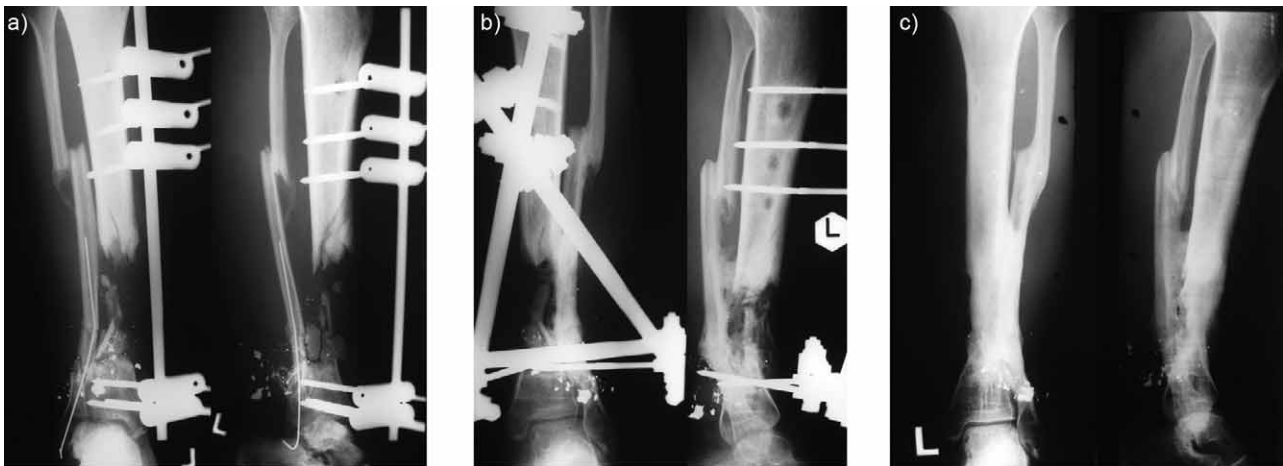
A 25-year old man sustained a type IIIB open tibial fracture as a result of war injury. Anteroposterior and lateral radiographs show a) the fracture after initial injury, b) seven months after central bone grafting, and c) fifteen years after central bone grafting with marked tibial recurvatum of 25 degrees.
